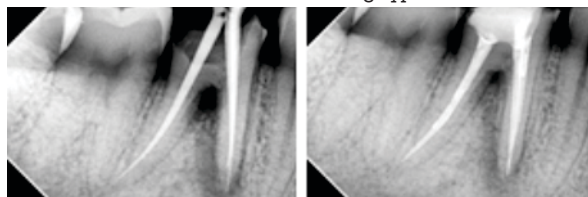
5(a) Master Cone Fit. 5(b) Post Obturation Radiograph
